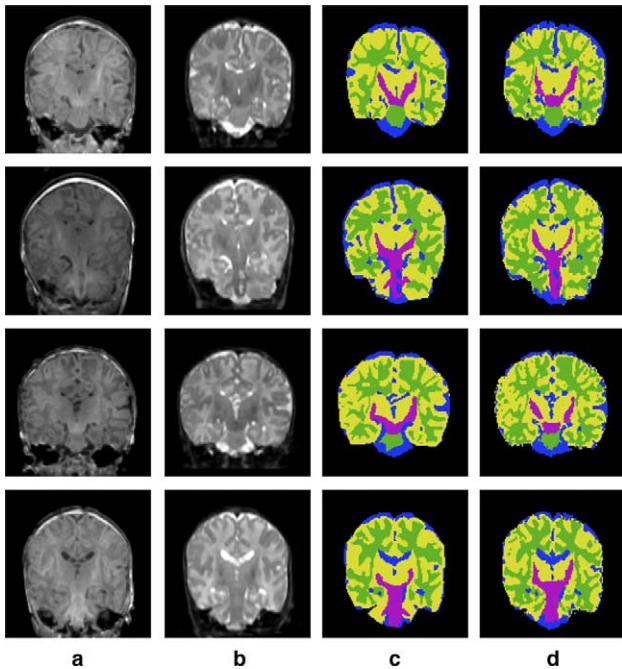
The MR images along with the manually segmented labels. From left to right: (a) T1w image, (b) T2w image, (c) color image showing the segmentation done by the first human rater, and (d) color image showing the segmentation done by the second human rater. Purple is myelinated white matter, green is non-myelinated white matter, yellow is gray matter, and blue is csf. From top to bottom: subject 0096, 0117, 0118, and 0123.
